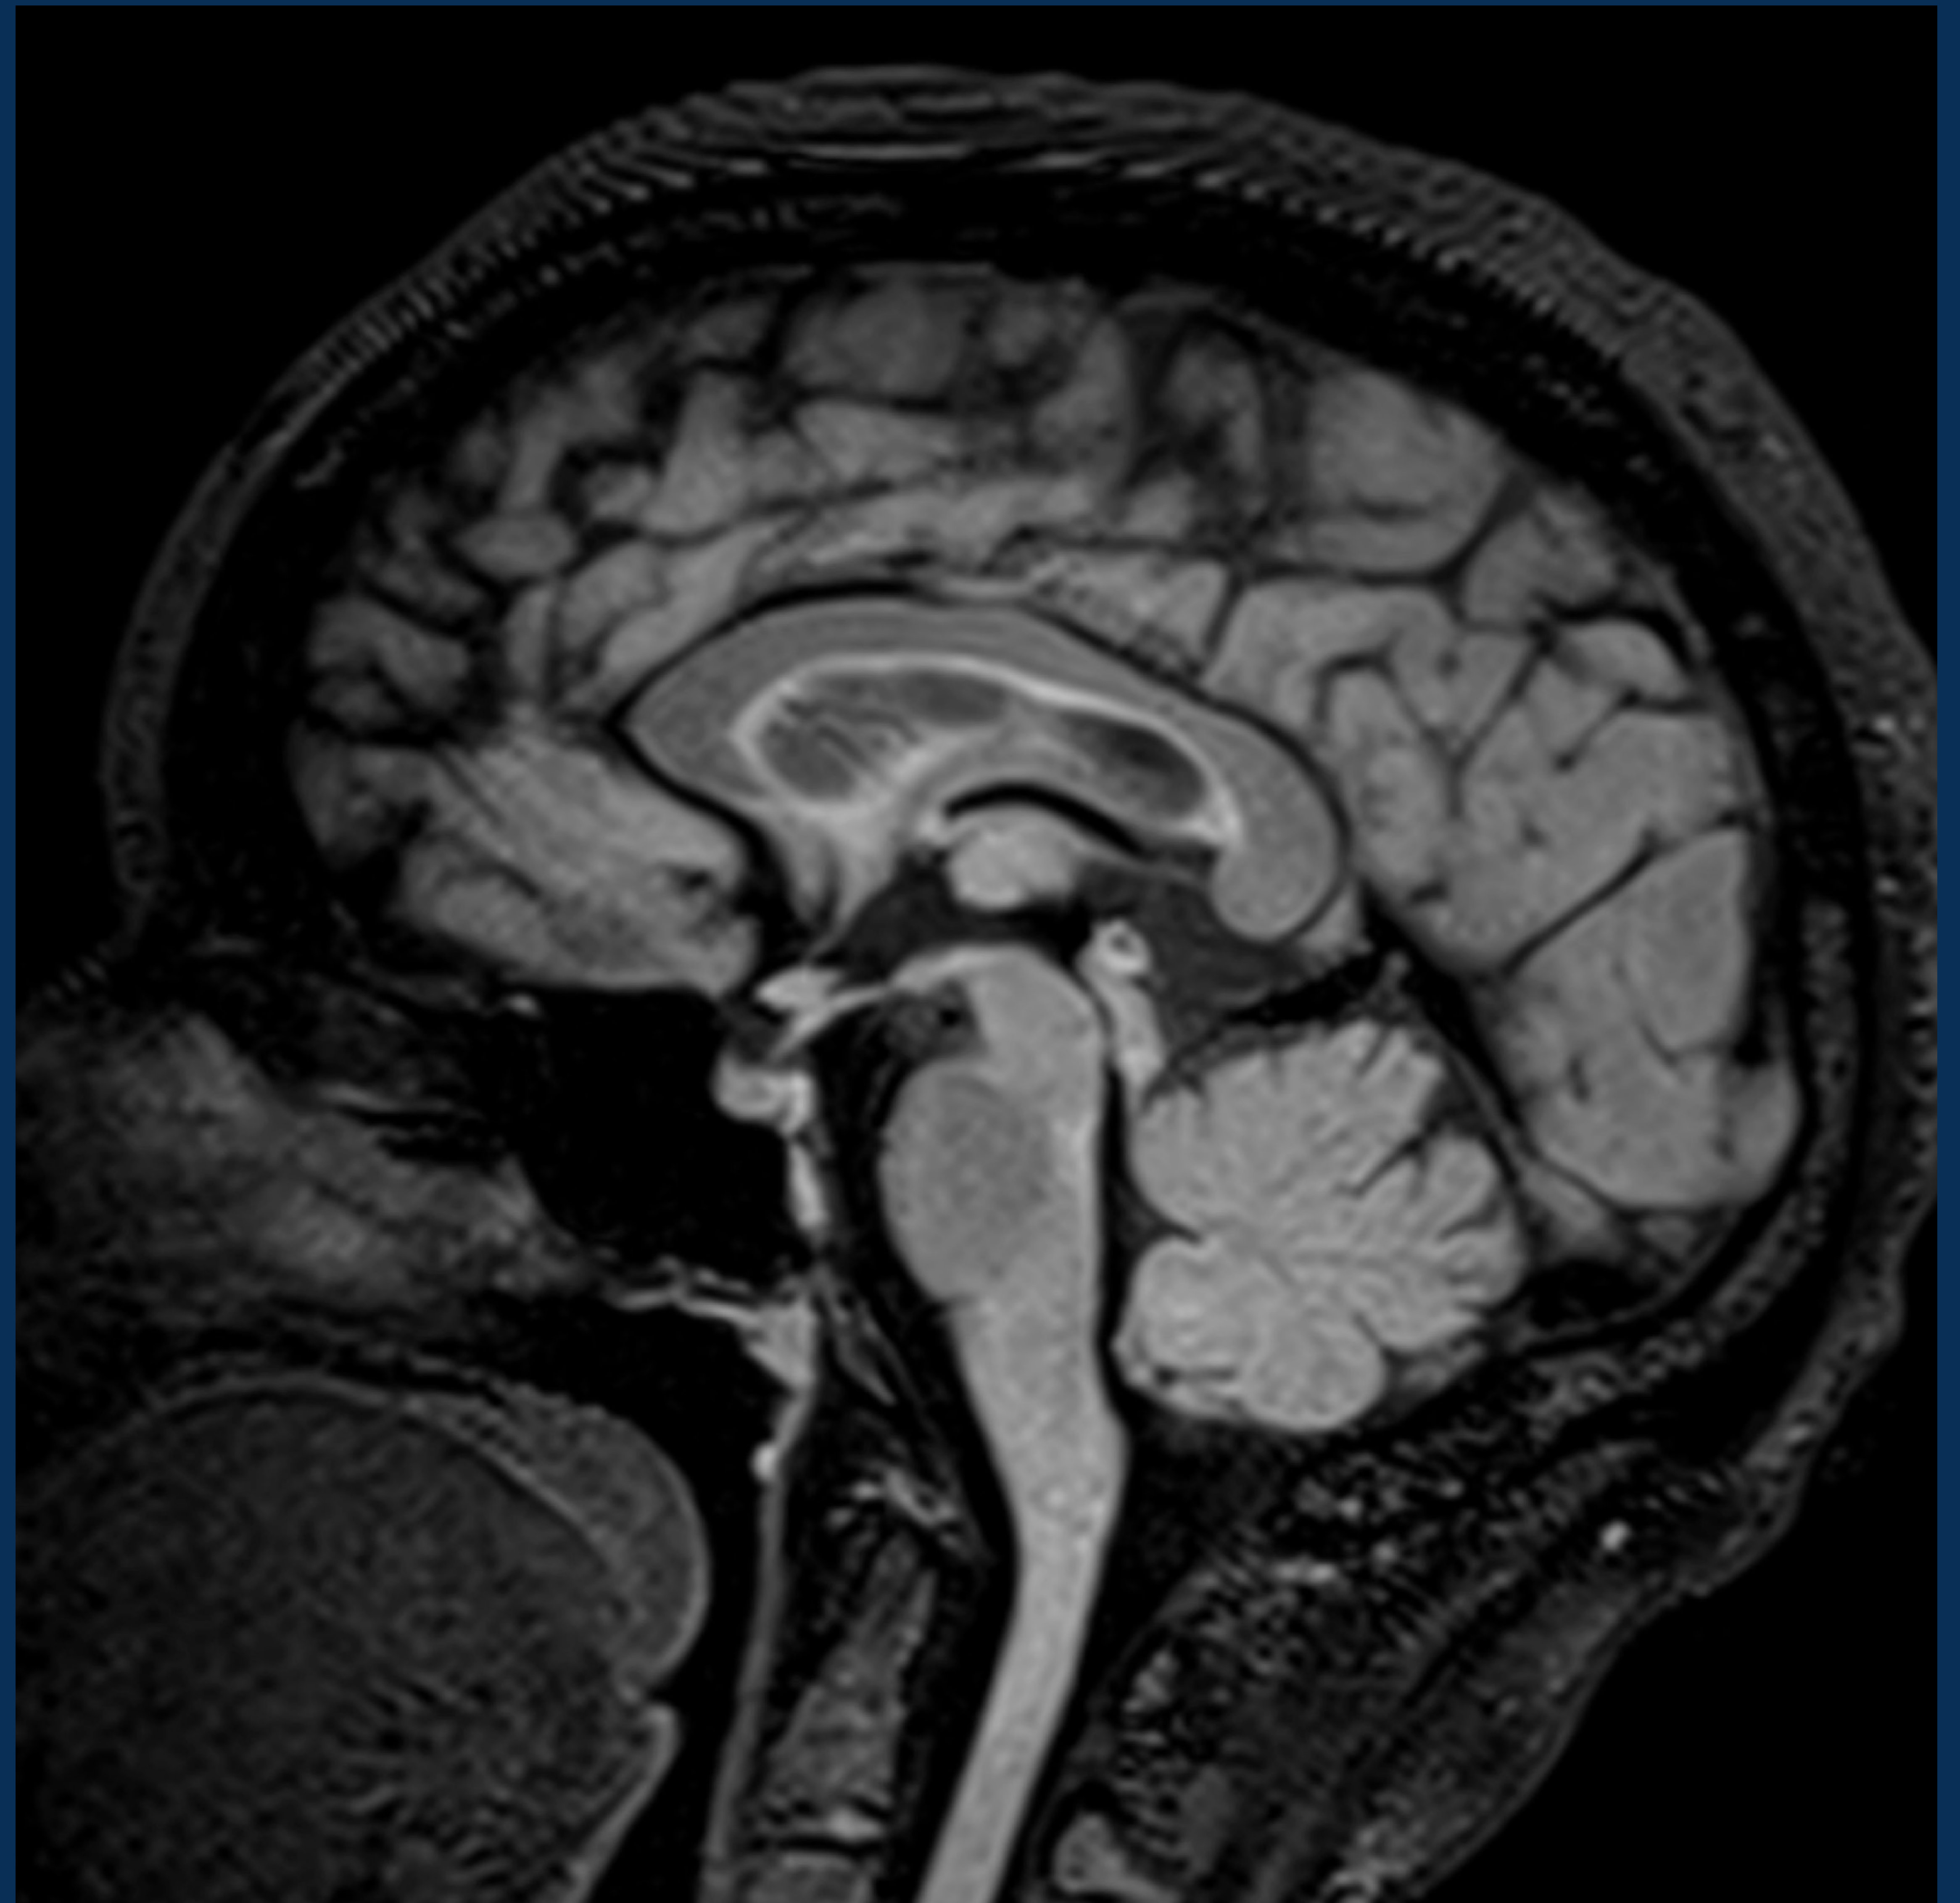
Sagittal T2 FLAIR of head four months after starting inebilizumab therapy.
